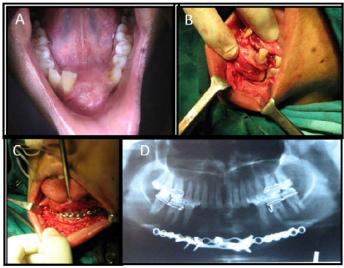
Management of segmental defect in anterior mandible. A. clinical photograph of ameloblastoma in anterior mandible. B. Intraoperative photograph of resection of ameloblastoma. C. and D photograph and radiograph of mandible after implant reconstruction.
